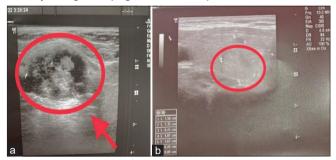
Ultrasound of the neck. (a) The thyroglossal duct cyst. (b) The thyroid nodule
